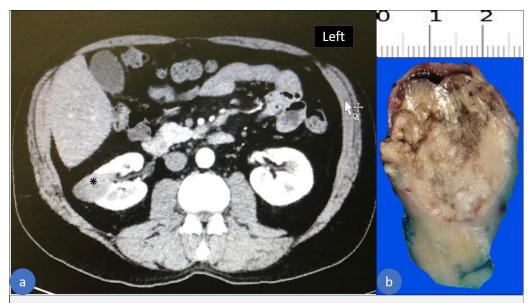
(a) CT scan, post contrast, with renal mass protocol showing a right kidney mass (marked with an asterisk), located in the lower pole of the right kidney. (b) Gross picture of the resected mass and part of the kidney, showing a variable solid and cystic cut surface.
